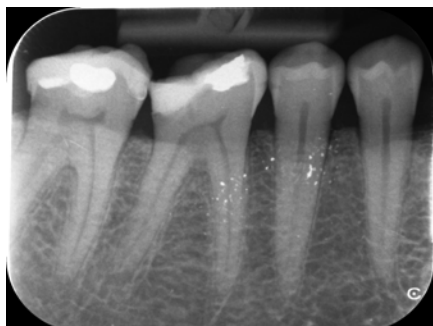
Radiography of quadrant 4 shows the suboptimal restorations on 46 and 47
